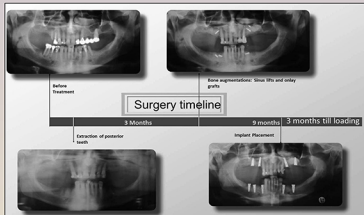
Surgery timeline showing pre- and post-treatment radiographs
